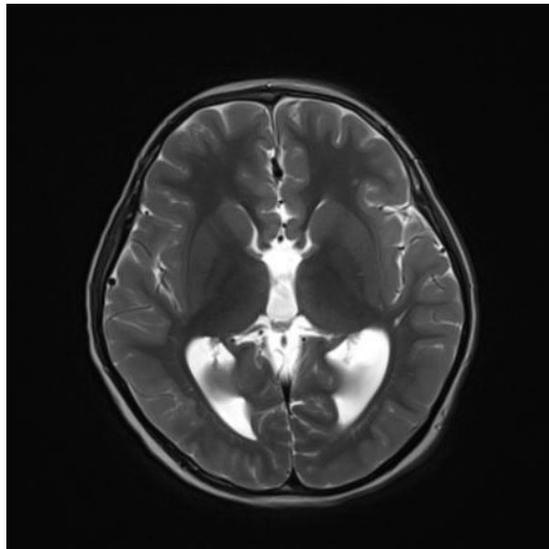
T2-weighted axial plane image showing the racing car sign
